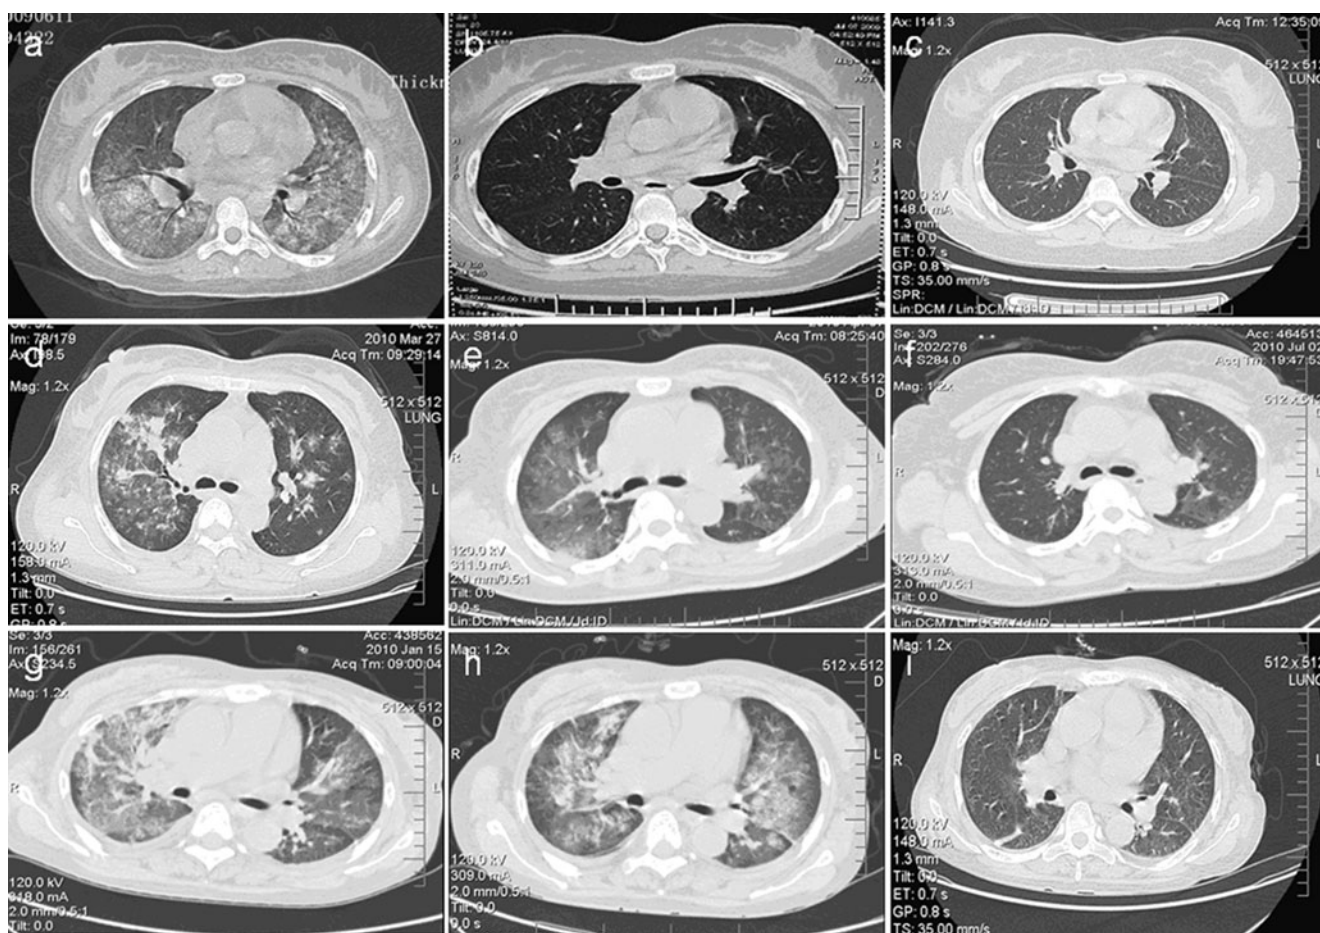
Chest HRCT scans before and after UC-MSCT. a, d, g An initial HRCT scan of the chest shows bilateral, diffuse alveolar infiltrates for patients 1, 3, and 4, respectively. b, e, h, One week after UC-MSCT, a repeat HRCT scan of the chest shows amelioration of the lung
